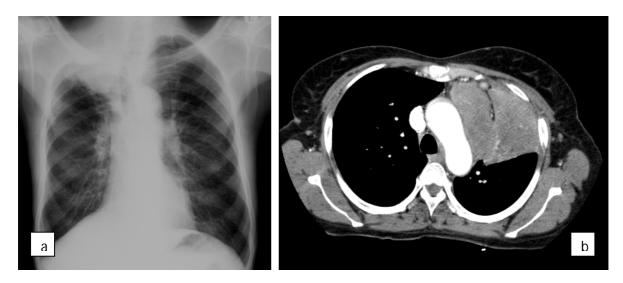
Chest X-ray shows a right apical lung tumour (a). Chest CT scan of large, peripheral lesion (b) with extension to the pleura, amenable to a TTNA.
